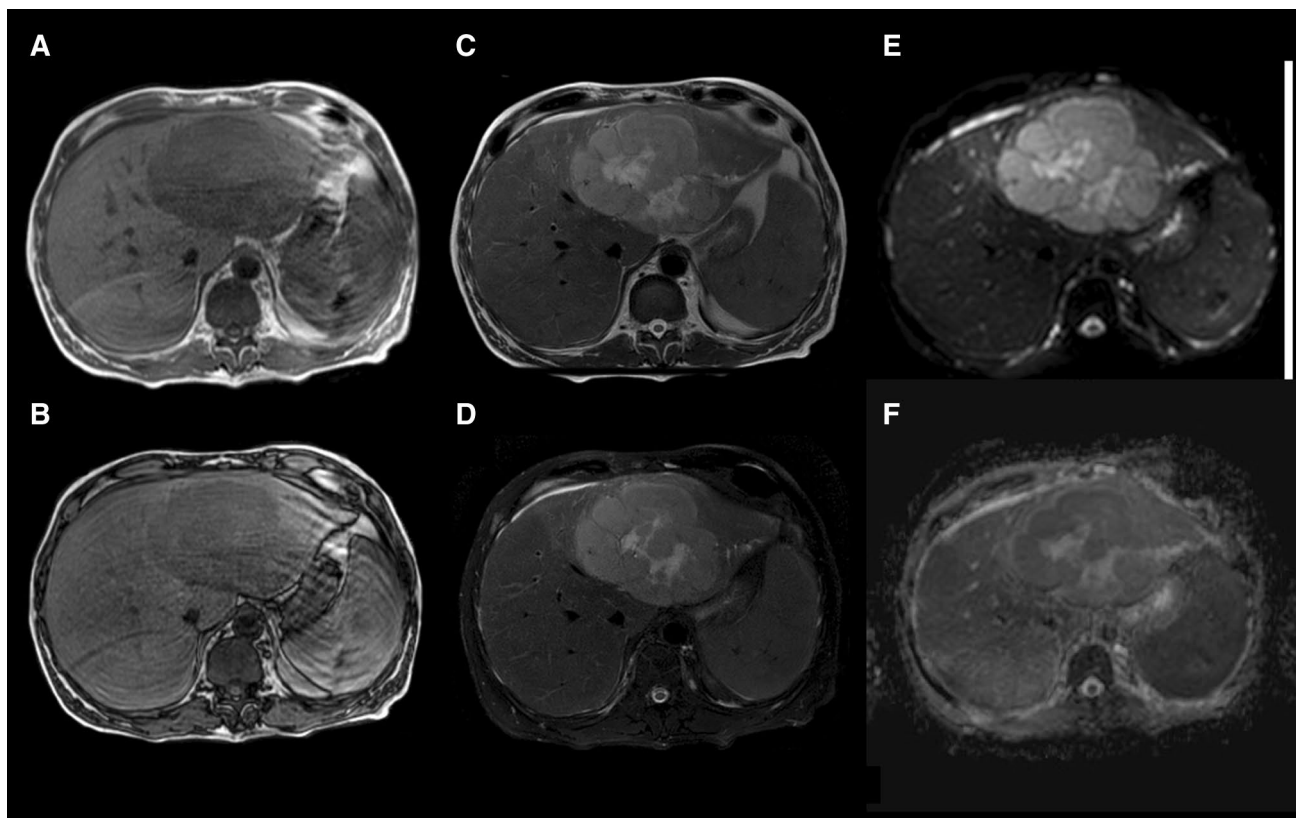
MRI images of a 47-year-old male patient with diagnosis of PHL. a, b In- and out-phase T1W images of a hypointense mass located in the left lobe. c, d T2W images with and without fat suppression of PHL characterized by inhomogeneous signal hyperintensity with well-defined margins and a hyperintense central fibrous
